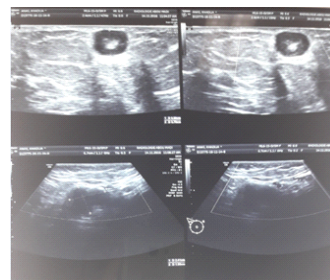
Ultrasound examination revealing a hypoechoic homogenous solid nodular formation
